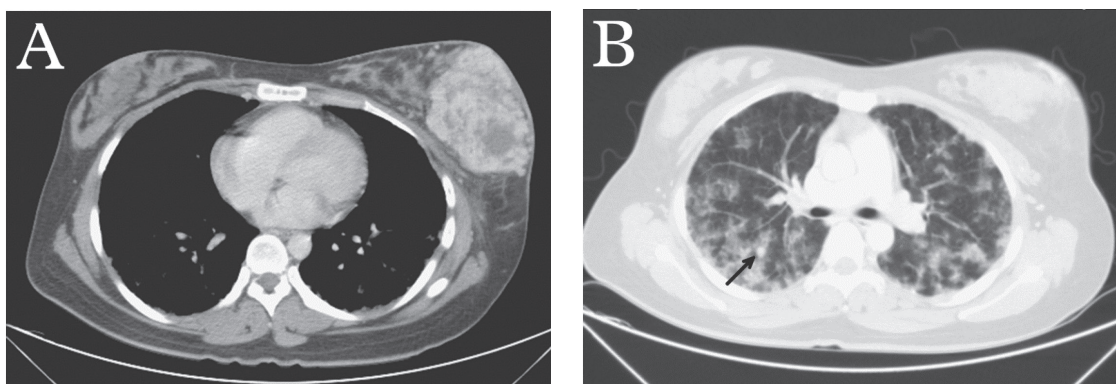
(A) Computed tomography scan image of breast with IV contrast showed a hypervascularity mass in the left breast. (B) On lung window setting, multiple nodular lesions (arrow) and diffuse ground-glass patches in both lung fields were found.
